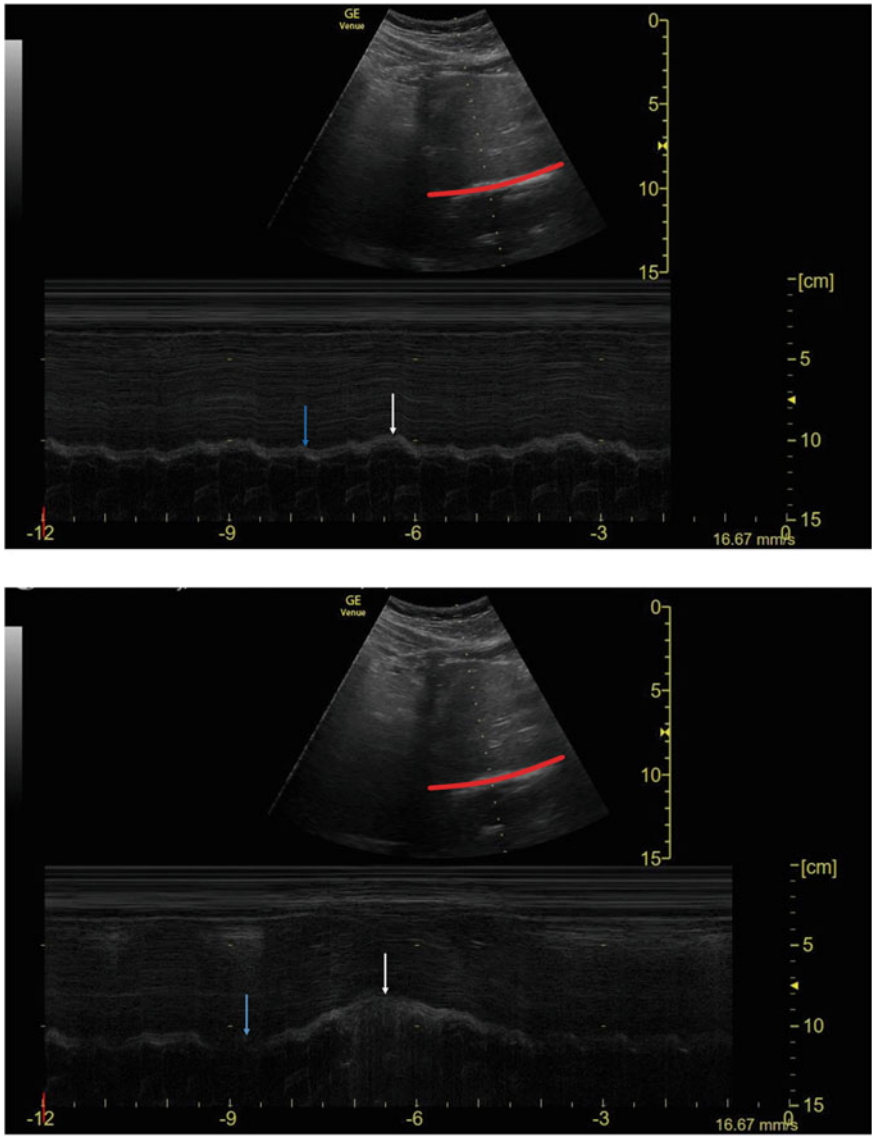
a M mode ultrasound through dome of hemidiaphragm (HD) during normal respiration; The dome of the hemi-diaphragm is demarcated with the red curve; the blue arrow demonstrates the position of the HD on expiration and the white line on inspiration. b M mode ultrasound through dome of HD during deep inspiration; the blue arrow demonstrates the position of the HD on expiration and the white line on deep inspiration.
